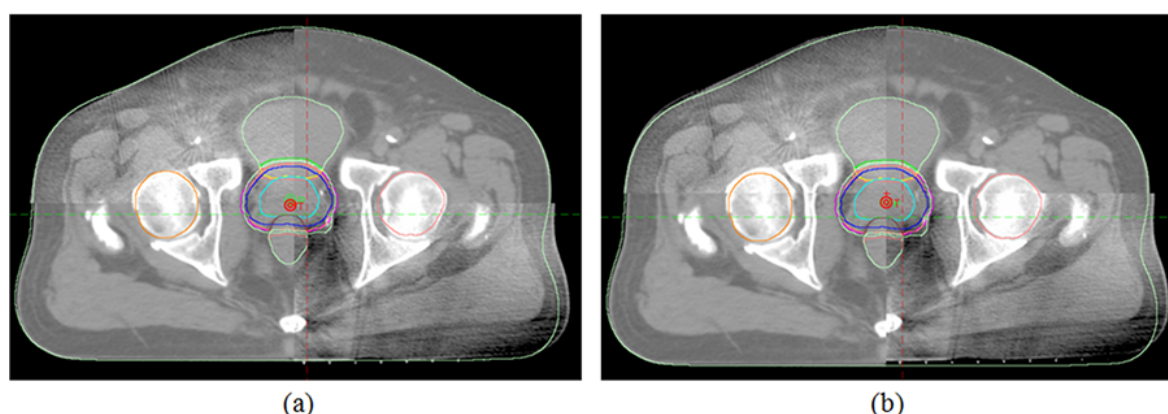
Offline review showing overlaid images for bony anatomy (a) and soft tissue prostate (b) matching between reference and CBCT images.
